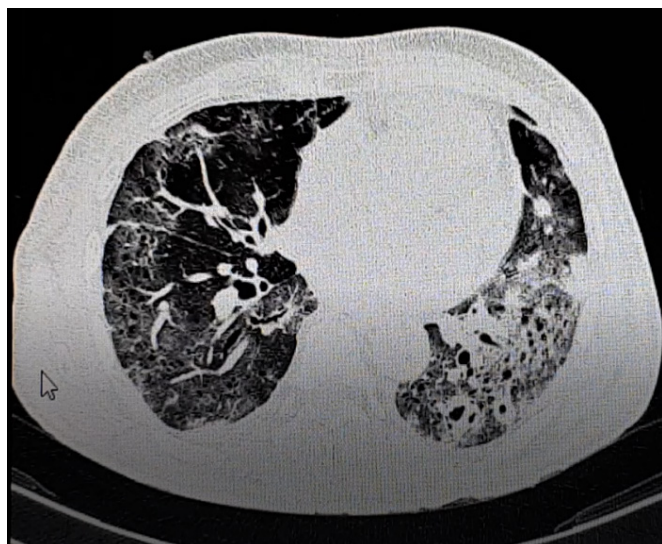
Chest CT Scan showing ground glass appearance on right lower lobe with cavitary lesion on left lower lobe
